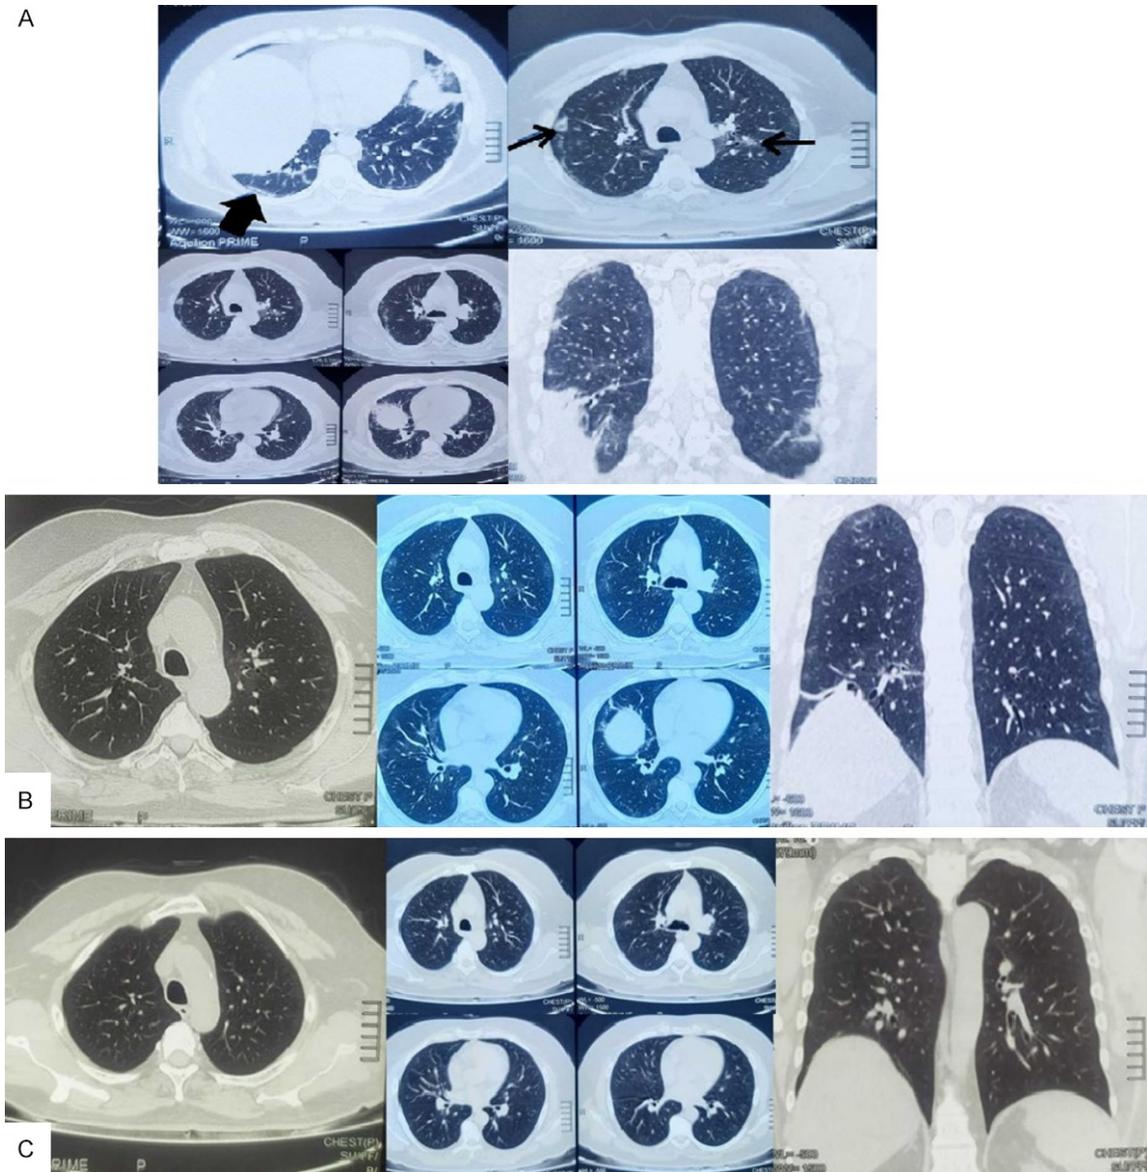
Comparative HRCT scan images of Day 1, Day 7 and Day 28 showing significant reduction in the ground glass opacities and atelectatic changes on Day 7 and complete resolution of ground glass opacities, subpleural lines and atelectatic bands on day 28.
